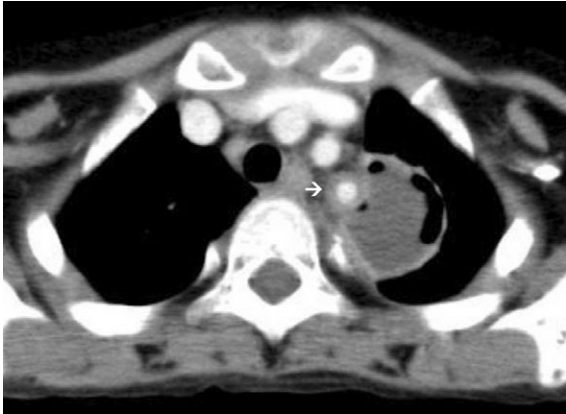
Axial CT image taken at a lower level shows thickened wall of proximal portion of the left subclavian artery (arrow), which adheres to the nodule in the left upper lobe.
